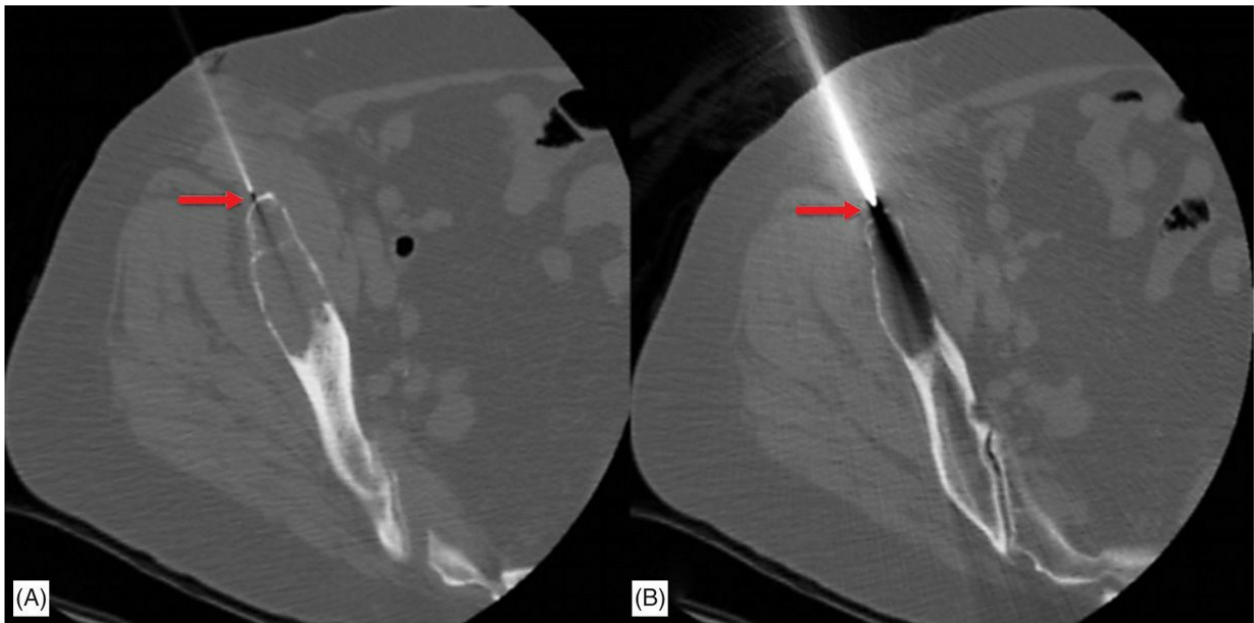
Demonstration of needle tip. (A) Axial CT during localization of local anesthetic needle reveals shadowing artifact arising from the tip, confirming identification of the needle tip. (B) With placement of the larger 11-gauge needle, a larger shadowing should be expected. The identification of the bevel of the needle tip is the most accurate method to localize the needle tip.
